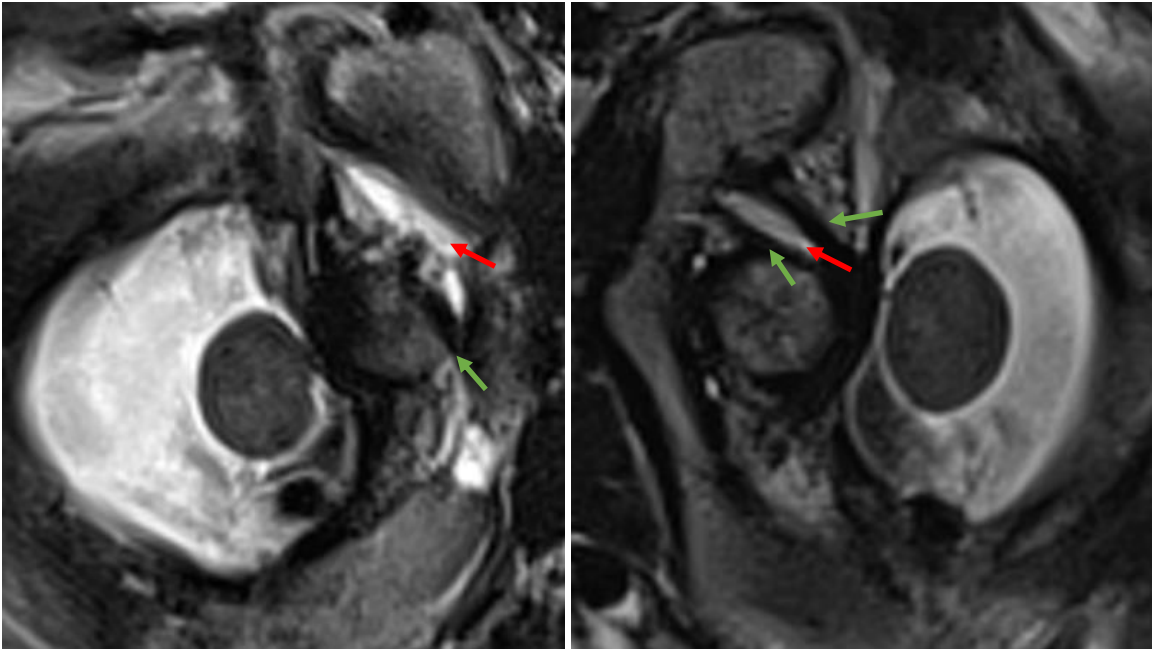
3T MRI, T2-weighted axial TSE at the level of the upper part of the dens axis-atlas. The left figure shows C1-2 rotation to the left (mirrored), the right figure shows C1-2 rotation to the right (mirrored). We focus on the ligament complex of the alar- cruciatum. With rotation to the left (left figure) we straighten mostly the right side of the ligament complex – and vice versa.
